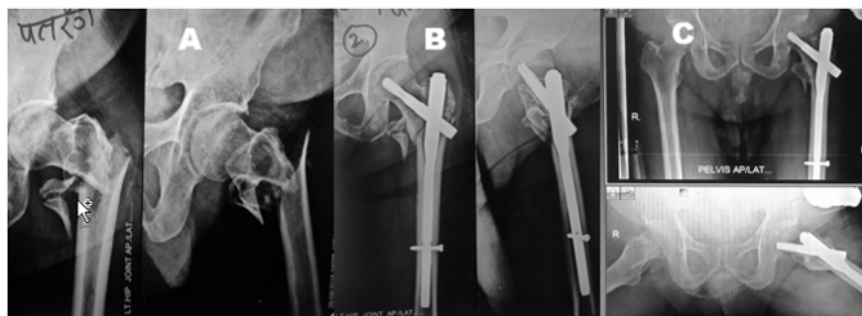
(A) Reverse oblique fracture A3 Fracture; (B) Post-op x-ray; (C) One year follow up. Good union.
